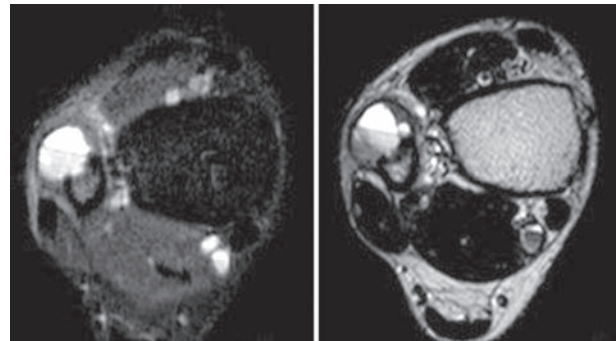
STIR-weighted (on the left) and T2-weighted (on the right) Magnetic Resonance Imaging after application of gadolinium showed fluid-fluid levels that are suggestive of aneurysmal bone cyst
